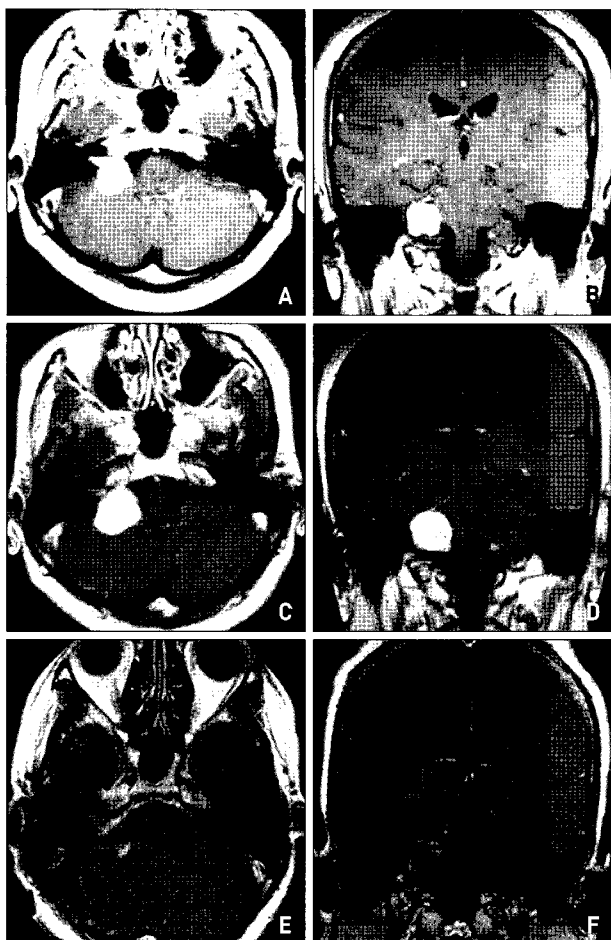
A 35 year-old female patient was diagnosed with vestibular schwannoma. Magnetic resonance images showed well enhanced mass at at right cerebellopontine angle (A, B). The tumor volume was 5 cc and treated by gamma knife radiosurgery (GKS) with 12 Gy marginal dose. At 4 years after GKS, the tumor size was increased with decreased hearing (C, D) and then the mass was removed by microsurgery. Post-microsurgical magnetic resonance images (E, F).
